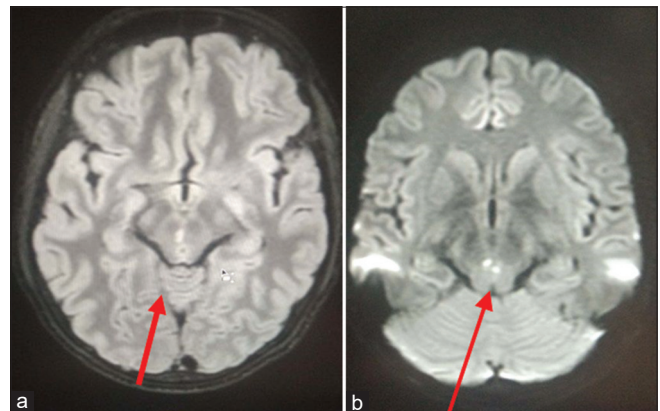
(a and b) MRI (Diffusion weighted imaging) images showing hyperintense foci in the midbrain suggestive of infarcts (Arrows pointing towards the pathology)
